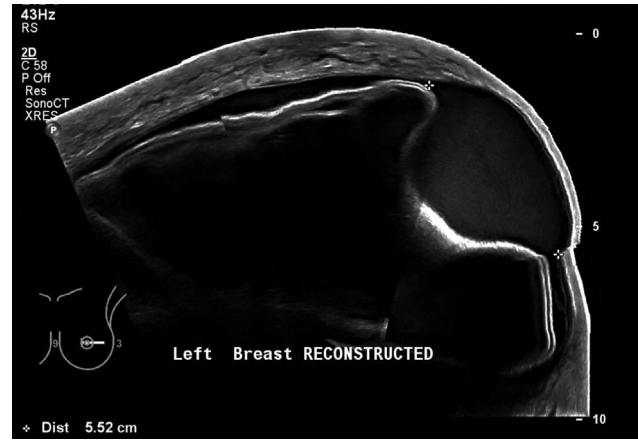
Ultrasound imaging showing a large 13.5 × 5.5 × 3.3 cm fluid collection at the 3 o'clock position.
